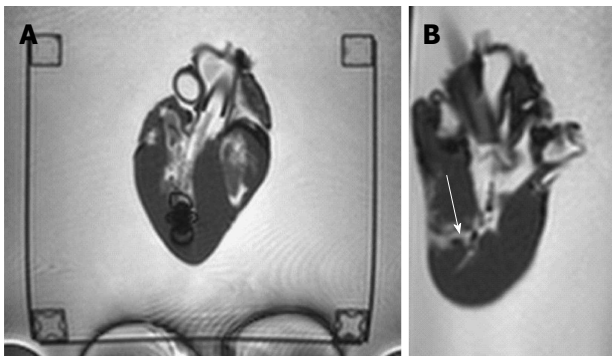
Side by side comparison of initial (A) and improved (B) version of magnetic resonance imaging compatible biptome. Note the huge artifact in (A). The tip is highlighted in the circle. The targeted region is marked by previous Gadolinium injection (arrow).
